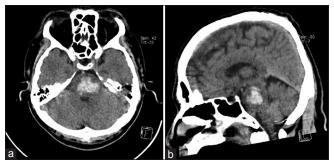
Computed tomography scan of the brain at admission revealed a large hematoma involving the basis and tegmentum of the pons predominantly on the left side. (a) axial view, maximum hematoma diameter of 3.6 cm. (b) Sagittal view, the hematoma extended along the lower midbrain to the pontomedullary area
